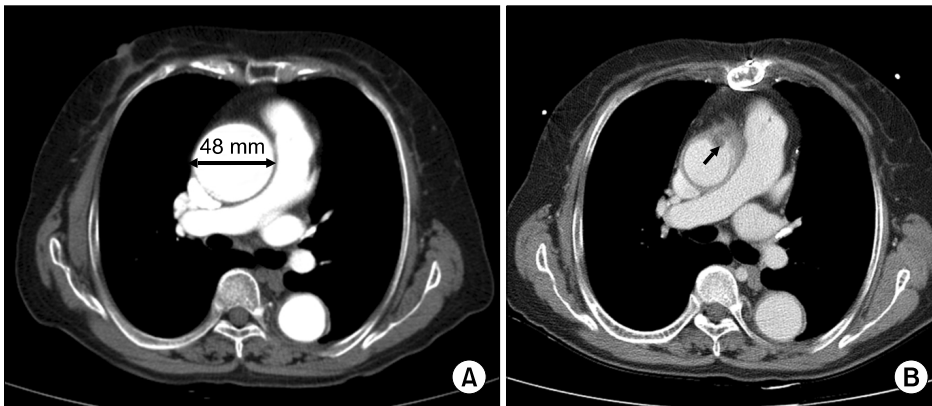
Computed tomography (CT) findings of the patient. (A) Preoperative CT showing the ascending aorta aneurysm with a maximal diameter of 48 mm. (B) Postoperative CT showing a normally sized ascending aorta. Inward folding of the intima is marked with a black arrow.
